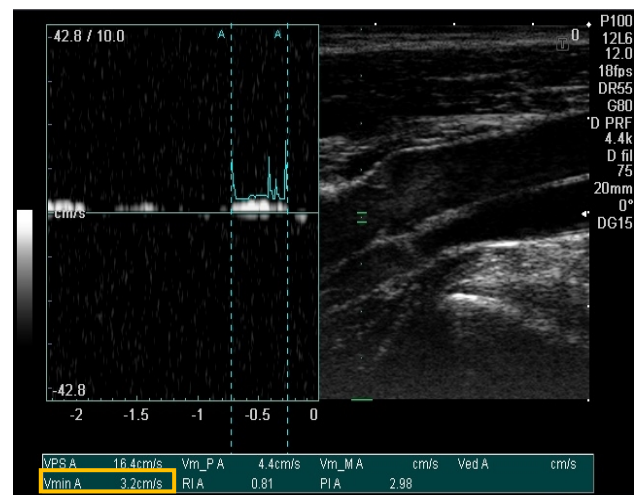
Velocity measurement of the subject using pulse Doppler ultrasound.
